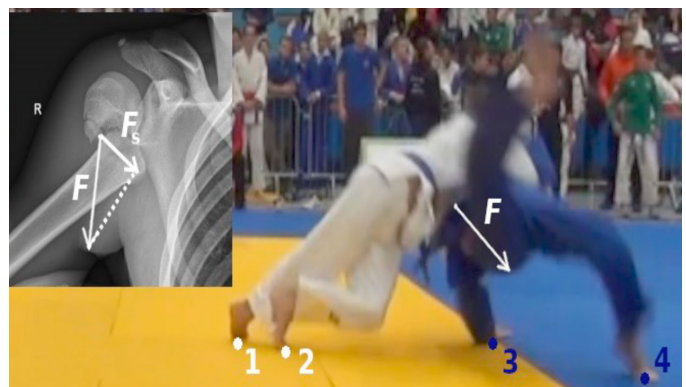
Snapshot from video footage capturing the moment of the fall of the *judoka*; when *uke* suffered an injury. The approximate net force (F) exerted by *tori* on the right shoulder of *uke* is indicated. The approximate points of contact with the ground are indicated for *tori* (points 1 and 2) and *uke* (points 2 and 3). INSET: Radiograph of the injury with indicated approximate force F and its component in the epiphyseal plate that could have caused epiphysiolysis.
